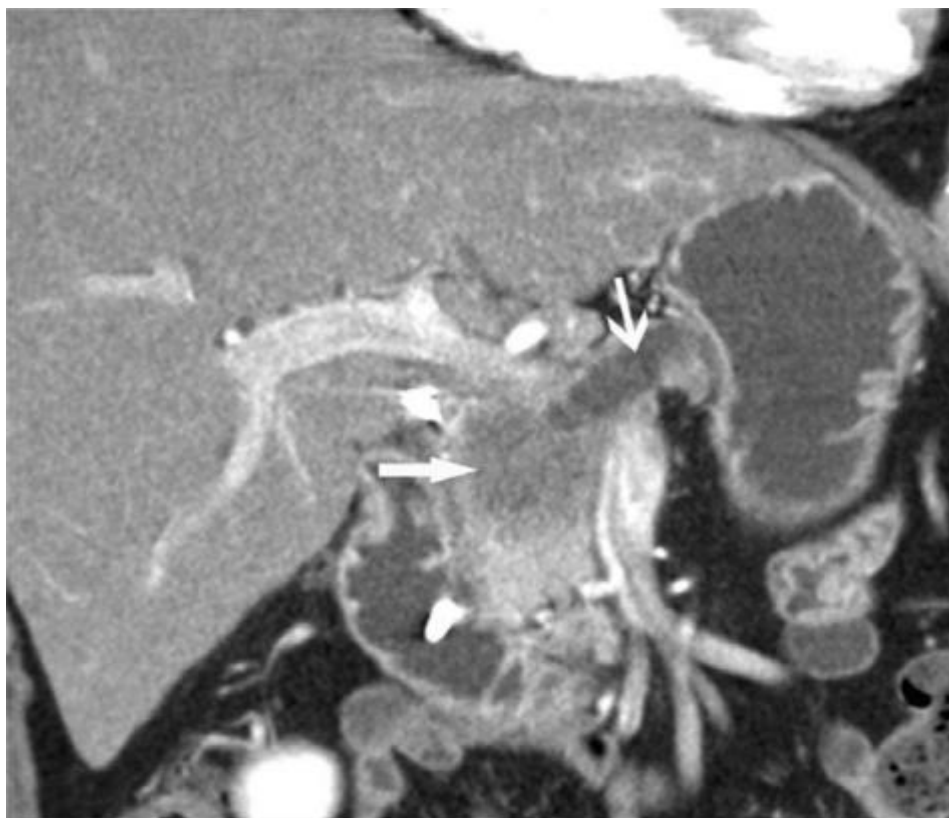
Coronal reformatted CT image depicts dilated pancreatic duct (arrowhead) due to obstructing tumor (arrow) in the pancreatic head.
